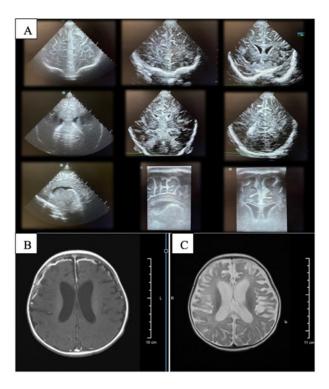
Cranial Ultrasound. The sulci are thick, irregular and hyperechoic, within the interhemispheric fissure and bilateral convexity consistent with Bacterial meningitis with ependymitis. Cranial MRI plain with contrast (T1 with contrast (B) and T2(C)). There is abnormal enhancement of the dura overlying both anterior frontal and left medial frontal lobes suggestive of Pachymeningitis.
